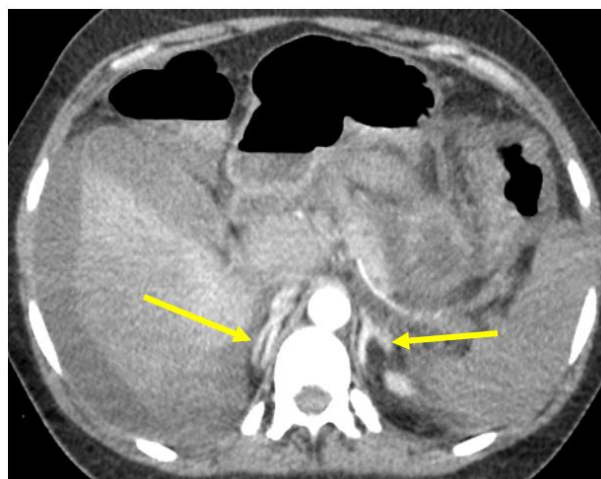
CT scan in early phase acquisition (arterial) demonstrates intense bilateral adrenal enhancement (yellow arrows), consistent with signs of tissue distress
